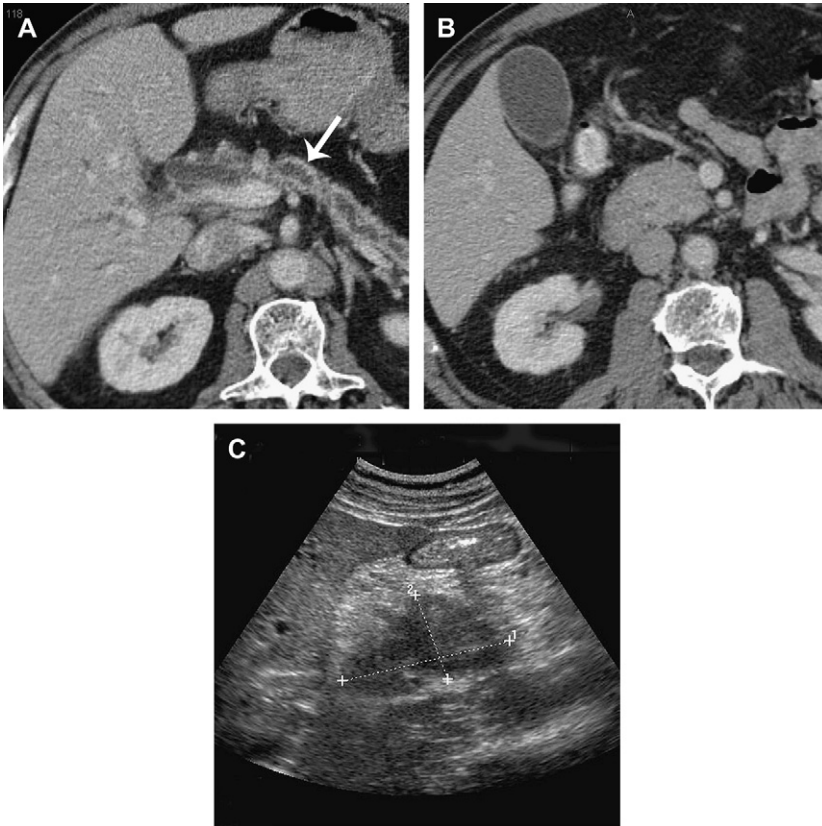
"Resectable" pancreatic head carcinoma. (A) Axial CT shows pancreatic ductal dilation (arrow) within the atrophic body and tail of pancreas. (B) Axial CT shows a rounded mass in the pancreatic head, with clear fat planes round the superior mesenteric artery and most of the mesenteric vein. (C) Endoscopic ultrasonography shows a hypoechoic mass (cursors) within the pancreatic head and showed no lymphadenopathy or vascular invasion.
